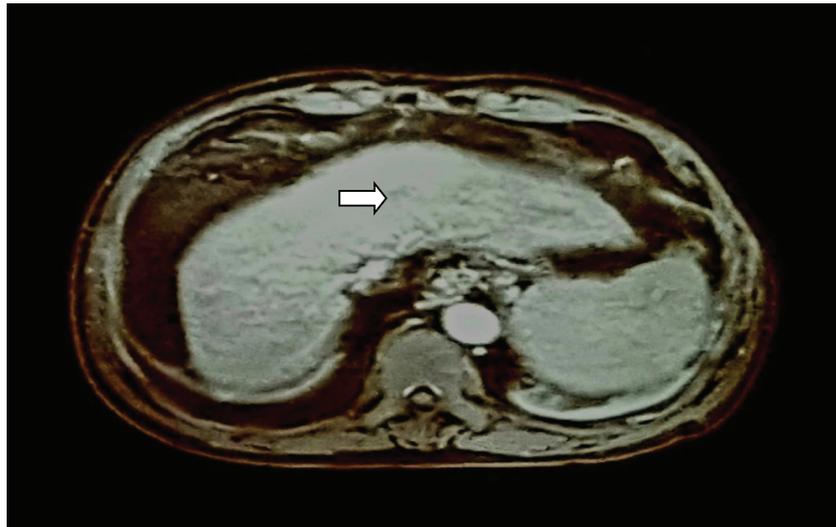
MRI image of small HCC nodule in hepatic cirrhosis.
